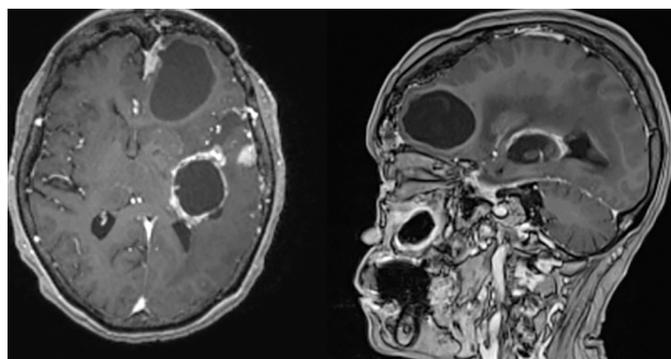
Axial and sagittal MRI views showing a heterogeneous solid and cystic intra-axial mass in the left temporal lobe measuring $5.0 \times 3.9 \times 3.4$ cm, and a dural based enhancement along the anterior falx in the left anterior cranial fossa with an associated cystic component in the left inferior frontal lobe measuring 4.4×4.1 cm.
